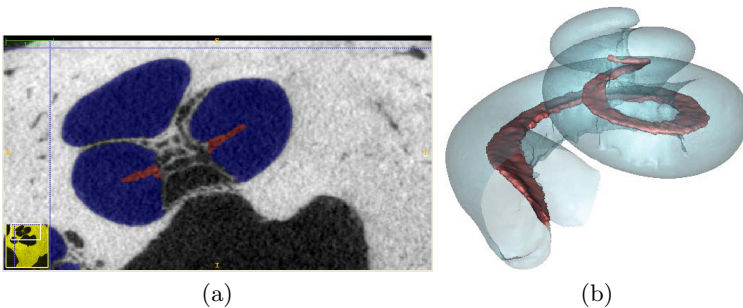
a) Segmented transversal slice of the μ CT, showing the cochlea (blue) and the spiral bone (red). b) Surface reconstruction of the cochlea, built from the μ CT image.
